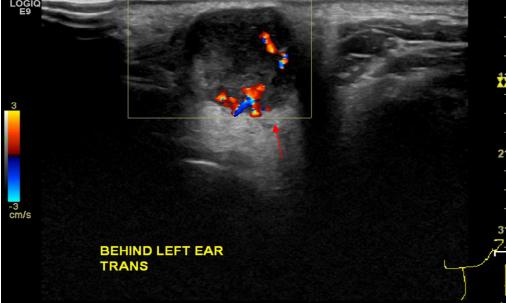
Ultrasound revealed a 2.3 cm x 1.5 cm x 1.6 cm hypoechoic oval mass with areas of color doppler flow suspicious for malignancy of parotid origin. Biopsy was recommended
